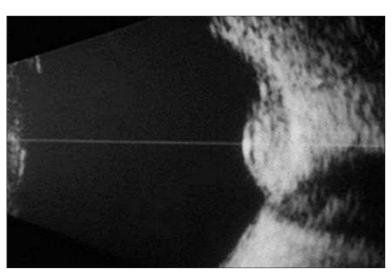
B-Scan Ultrasonography of Circumscribed Choroidal Hemangioma Shows Biconvex Cross-Sectional Shape of the Tumor, Moderately High Internal Sonoreflectivity of the Tumor, and Presence of Associated Overlying Serous Retinal Detachment.
